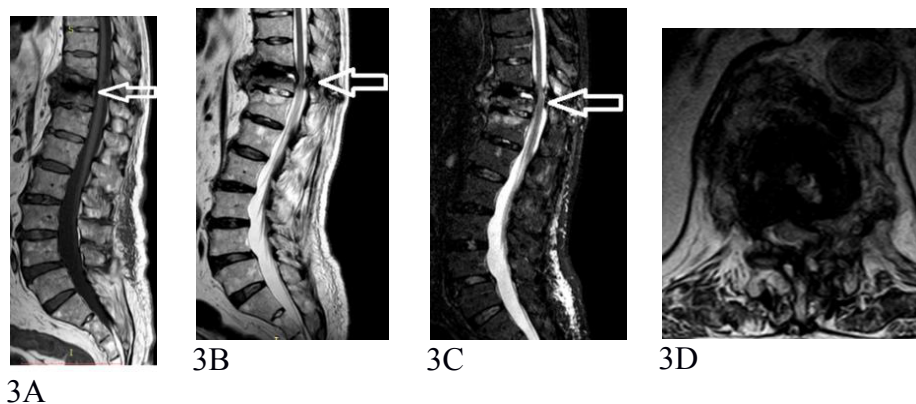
Radiological aspect 1 year after the trauma; MRI with sagittal sections T1 (3A), T2 (3B) and STIR (3C) and in axial section (3D). The development of a deformity in kyphosis, an exuberant bone reaction surrounding the collapsed vertebra and a vertebral canal stenosis with medullary compression at T11 level are obvious.
